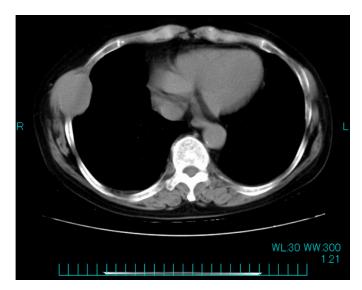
A rib tumor, 5.9x4.1 cm, demonstrated by computed tomography scan.
